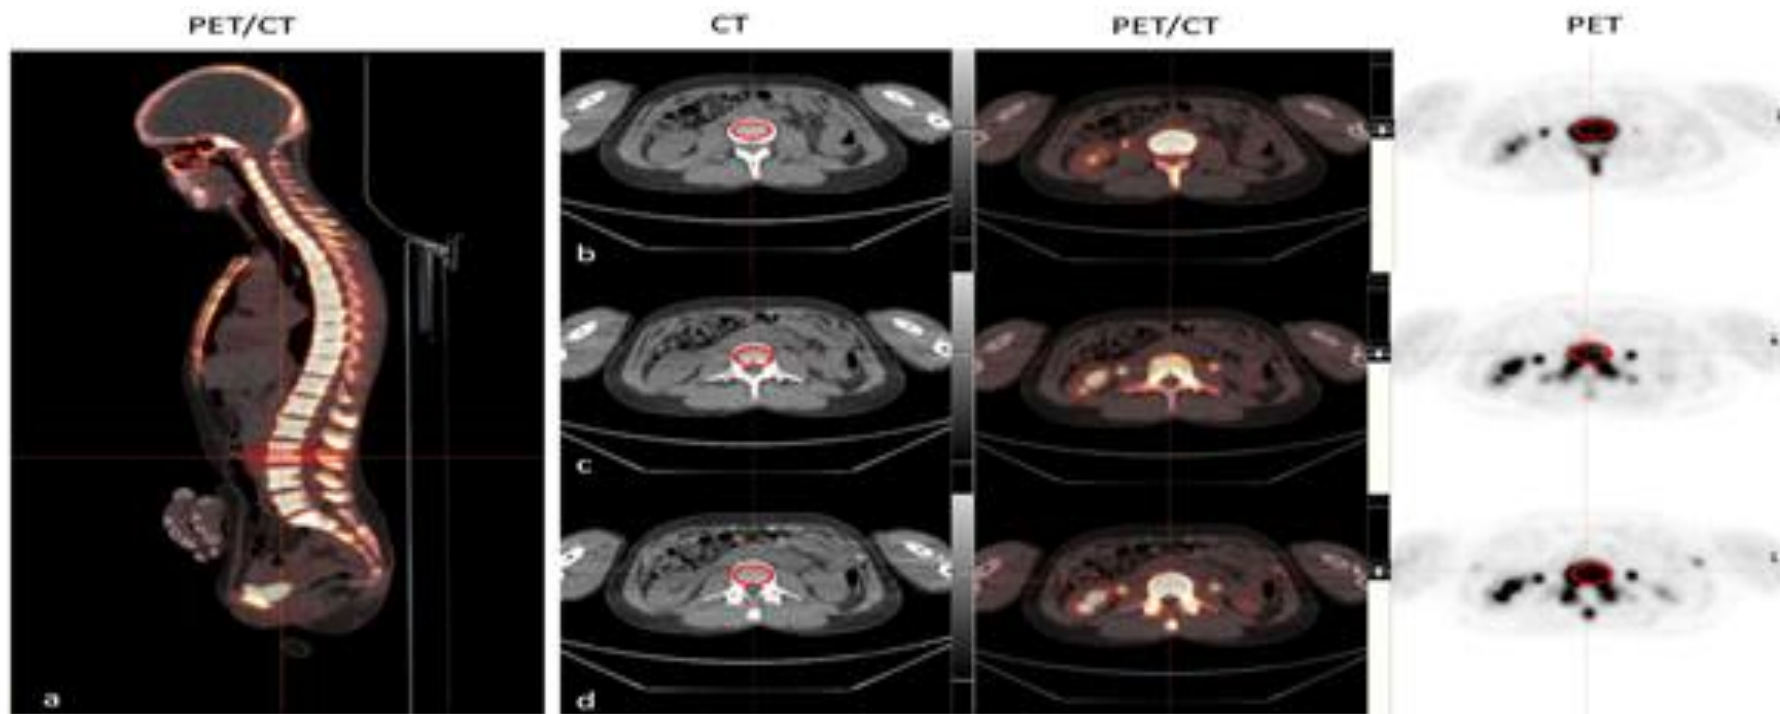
3D ^{18}F -NaF PET/CT scan of the spine.
